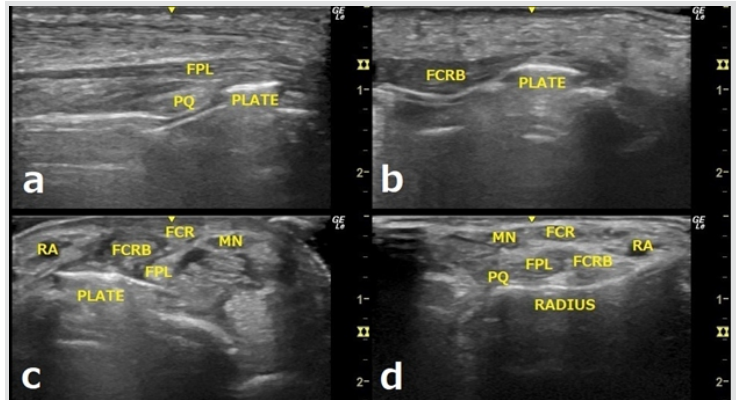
Case 3 ultrasound 3 months after surgery. (a,b): Longitudinal view of the right forearm after internal fixation. The shortest distance from the plate to the flexor pollicis longus was 0.05 mm, and the flexor carpi radialis brevis (FCRB) was in contact with the plate. (c): Axial view of the right forearm after internal fixation. The FCRB muscle belly was above the plate. The pronator quadratus (PQ) was unclear. (d): Axial view of the left forearm (unaffected side). An FCRB was observed. The PQ under the FCRB was unclear.
